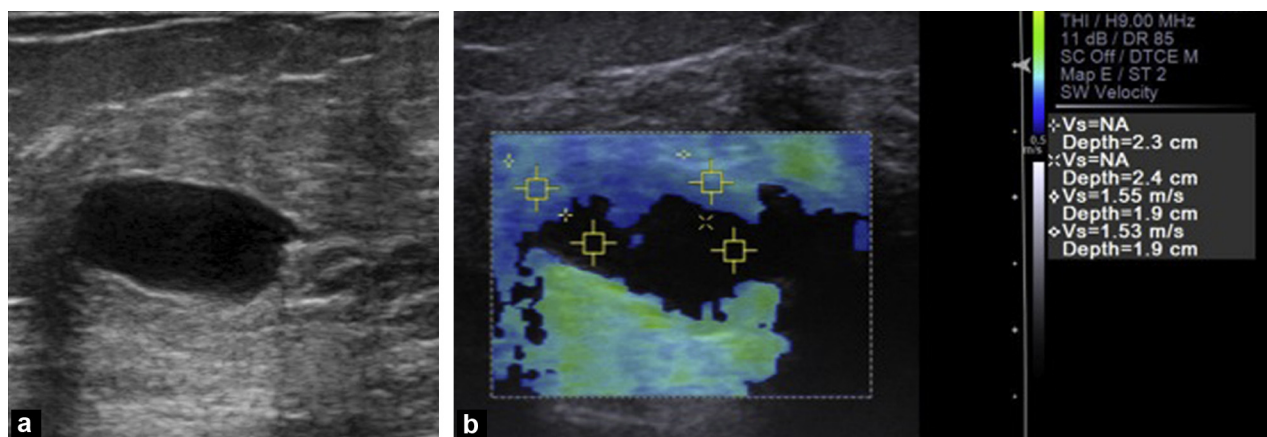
Cyst. Acoustic Radiation Force Impulse mode (Siemens®). The shear waves are not generated when the ultrasound beam encounters a pure cyst (a) as in this example. With this technique, the defect appears as an area of blank signal (b) although this elastographic feature provides the diagnosis. Speed measurement or kPa measurements cannot be done in the blank signal areas of the cyst.
